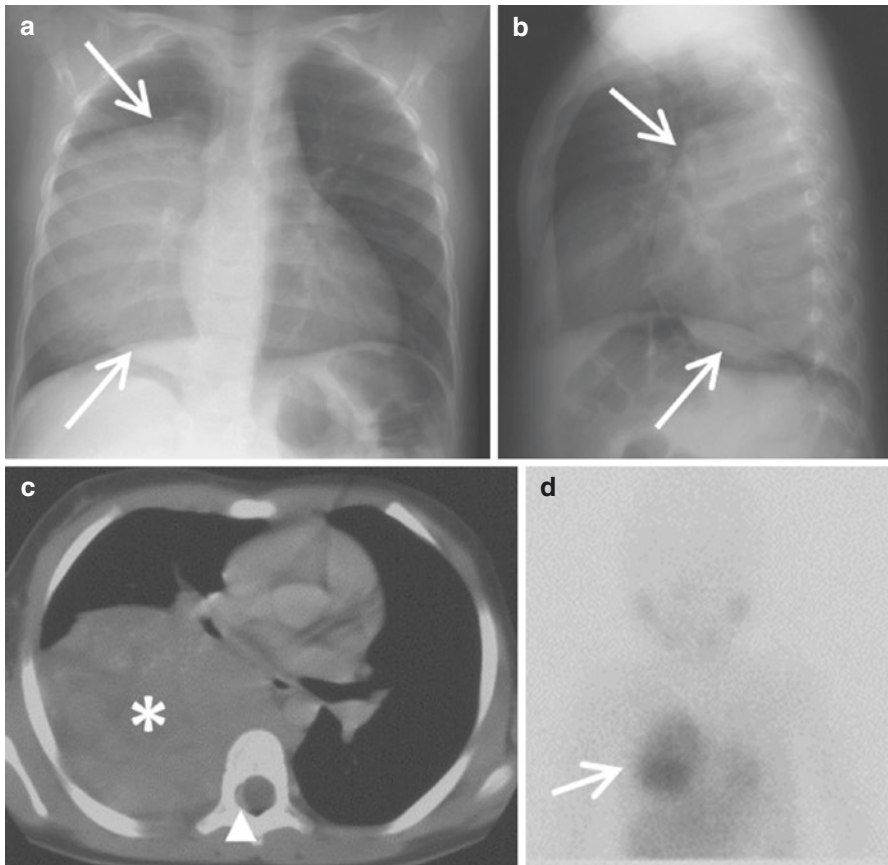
A 3-year-old girl with localized chest nodular ganglioneuroblastoma (INSS stage 1, INRGSS L2). Chest X-ray (a, b) showing a typical right posterior mediastinal mass (arrows). Contrast-enhanced CT-scan (c) transverse view. The tumour (asterisks) arises from the right paravertebral sympathetic chain and contains stippled calcifications. It displaces anteriorly the right bronchus. Intraspinous epidural invasion is visible as a thin enhanced crescent (arrowhead). MIBG scan (d) shows tumour uptake (arrow) without distant metastasis
